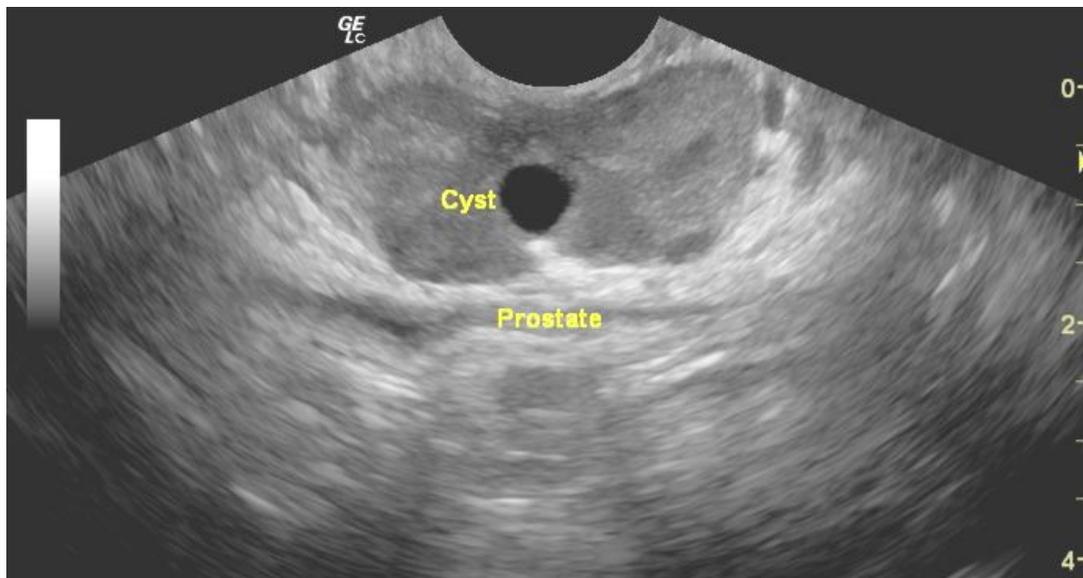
Image of ultrasound scanning of the prostate with cysts.
